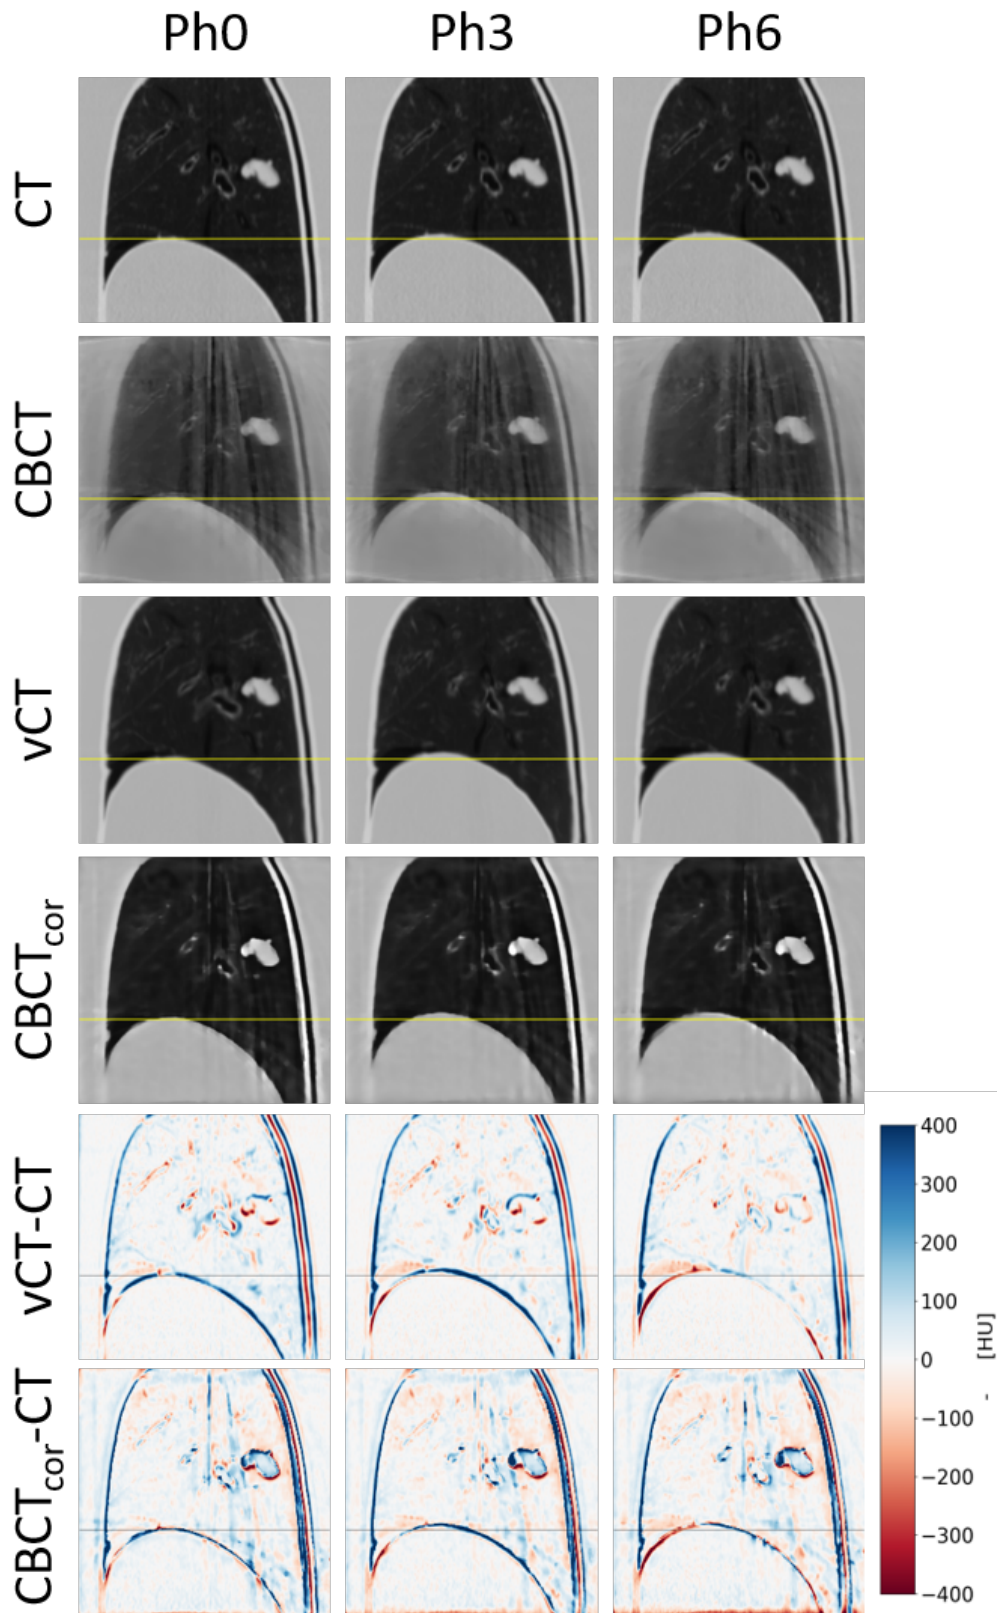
In the top four rows the four 4D images 4DCT, 4DCBCT, 4DvCT, and 4DCBCT_{cor} are displayed in phase 0 (inhale), phase 3, and phase 6 (exhale) with level = -300 and window = 1600. The bottom two rows show difference images of 4DvCT and 4DCBCT_{cor} to the reference 4DCT. All images are shown in a sagittal view. The horizontal lines indicate the diaphragm position at inhale.
